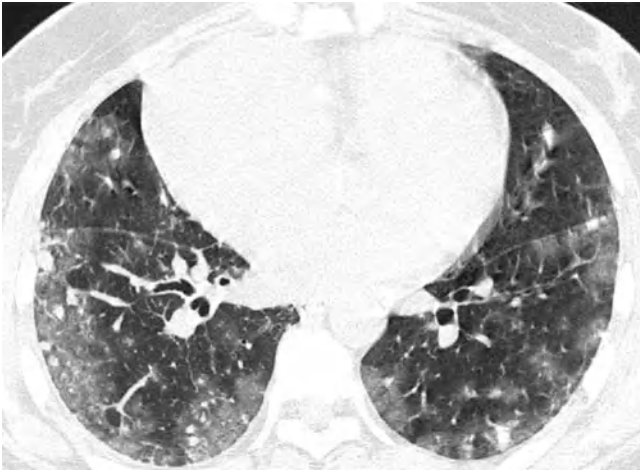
Hemorrhagic metastasis in a 52-year-old woman with renal cell carcinoma. Lung window of CT (5.0-mm section thickness) scan obtained at level of the interior pulmonary vein shows multiple solid nodules surrounded by ground-glass opacity, suggesting hemorrhagic metastasis
